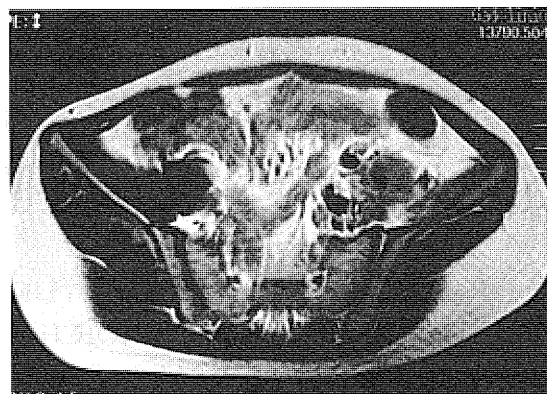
Abdominal MRI. T1-weighted images with gadolinium showed a heterogeneously enhanced mass in this lesion.
